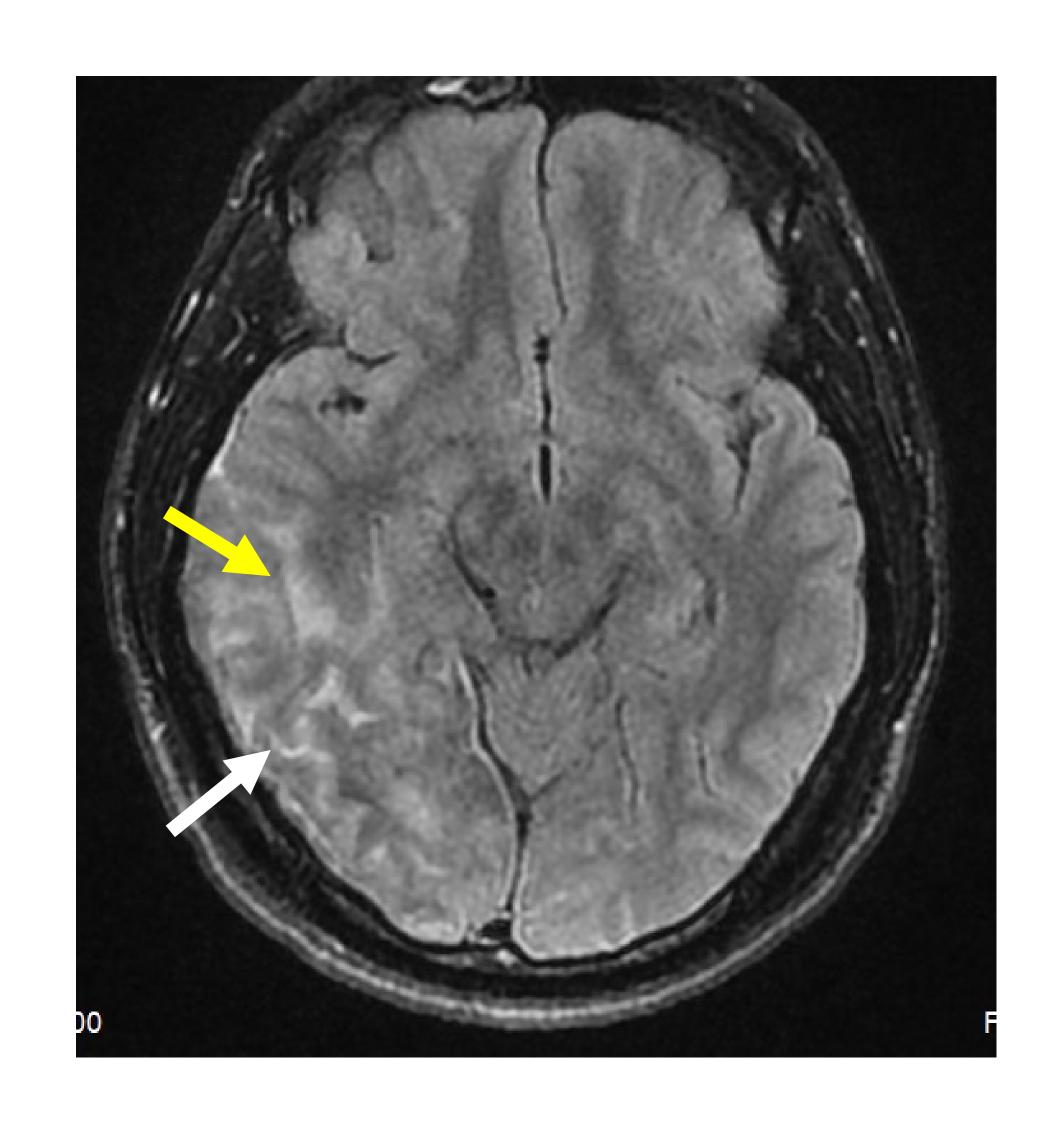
T2 FLAIR imaging demonstrated similar findings as Fig IV (white arrow). Additionally, there is subcortical edematous changes involving the right occipitotemporal lobe (yellow arrow).
